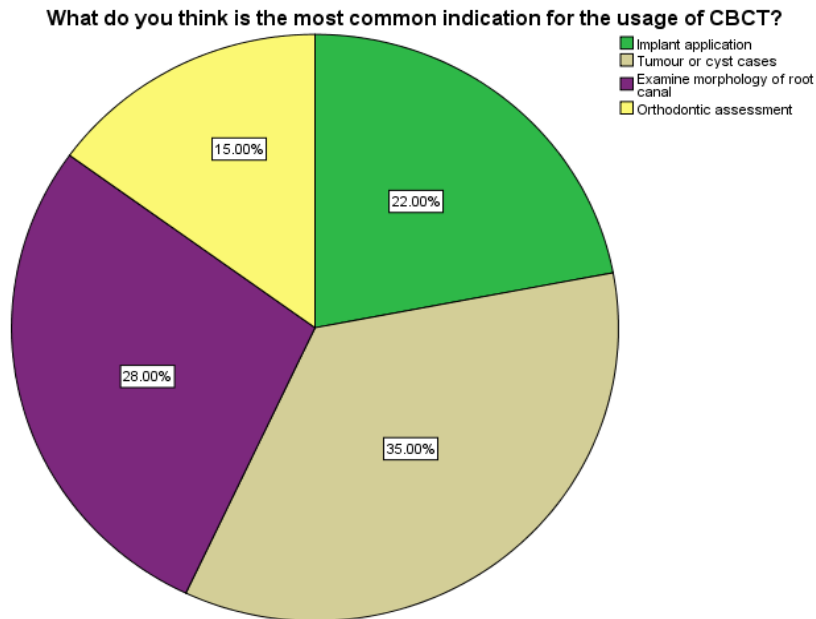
The pie chart represents the percentage distribution of participants responding on the common indication for the use of CBCT in which 22% (green colour) responded as implant application, 35% (beige colour) responded as tumour or cyst cases, 28% (violet colour) responded as examine morphology of root canal and 15% (yellow colour) responded as orthodontic assessment.
